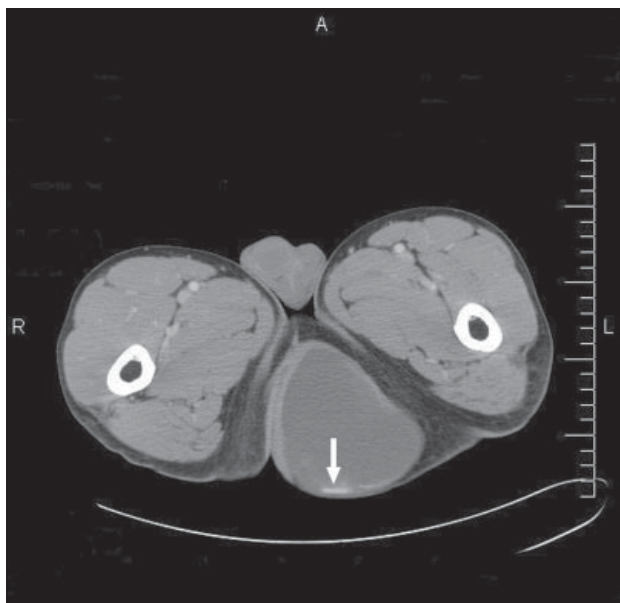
Postcontrast axial computed tomogram at the level of the perineum showing calcification (arrow) of the wall at the posterior aspect of the lesion.
